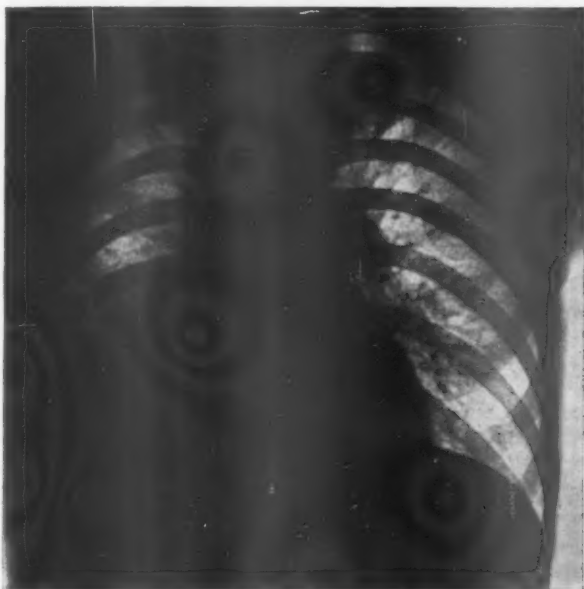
Radiograph of chest, January 20, 1936.
